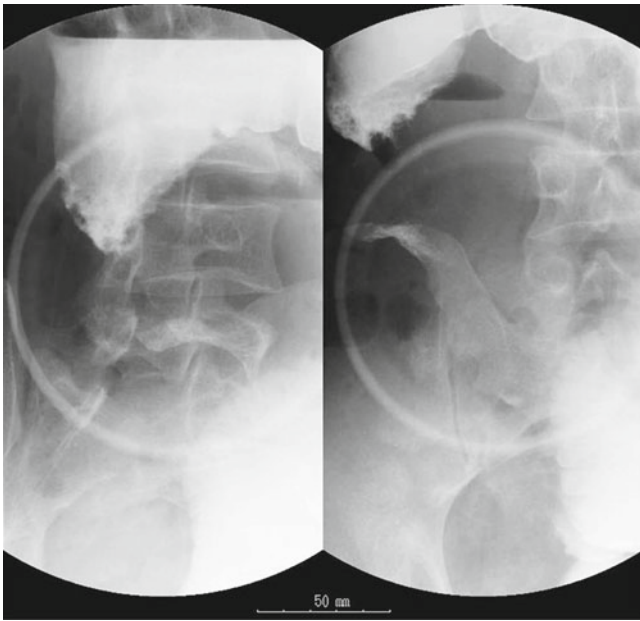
Radiography revealed stenosis in the neighborhood of the ileo-jejunal junction. The mucosa in front of the site of stenosis was irregular, with prestenotic dilation
